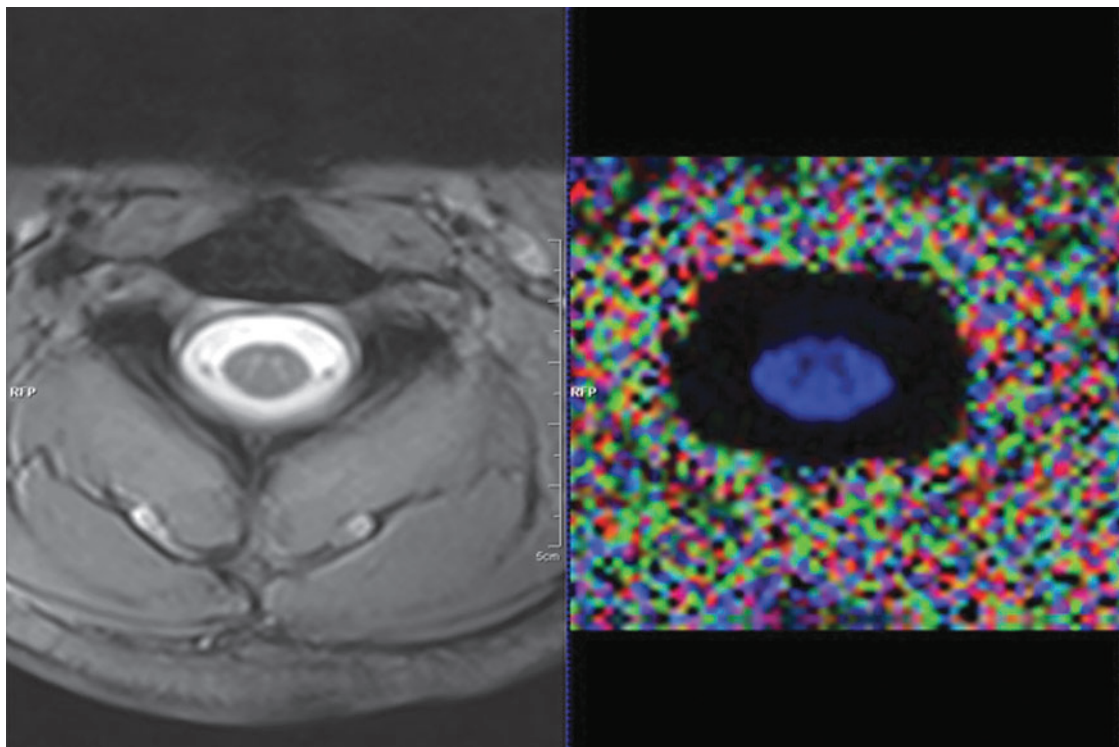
Cross-sectional image of the spinal cord acquired from the MRI scanner; T2 W-GRE image (left) and FA map reconstructed from raw DTI dataset (right). DTI, diffusion tensor imaging; FA, fractional anisotropy; MRI, magnetic resonance imaging; T2 W-GRE, T2-weighted gradient recalled echo. Color image is available online at www.liebertpub.com/neu
